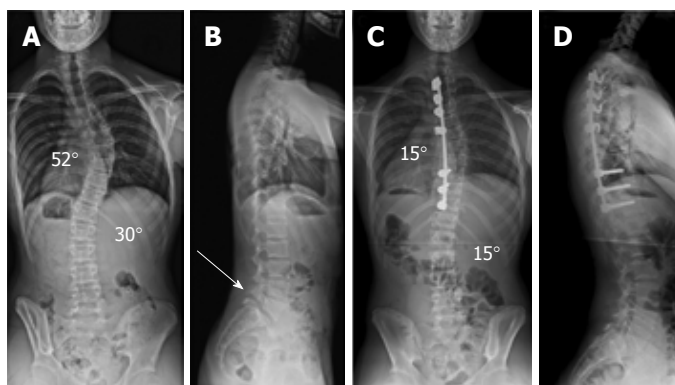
Patient with adolescent idiopathic scoliosis (patient 13; Table 4). A: Preoperative postero-anterior spinal radiograph shows a primary thoracic and compensatory lumbar AIS; B: Preoperative lateral spinal radiograph shows thoracic hypokyphosis and isthmus spondylolysis at L5 (white arrow) with associated grade 1 lumbosacral spondylolisthesis; C: Postero-anterior spinal radiograph shows very satisfactory scoliosis correction across both curves and a globally balanced spine following a selective posterior thoracic fusion; D: Lateral spinal radiograph shows restoration of thoracic kyphosis and a normal sagittal balance of the spine with no change in the grade 1 lumbosacral spondylolisthesis. AIS: Adolescent idiopathic scoliosis.
